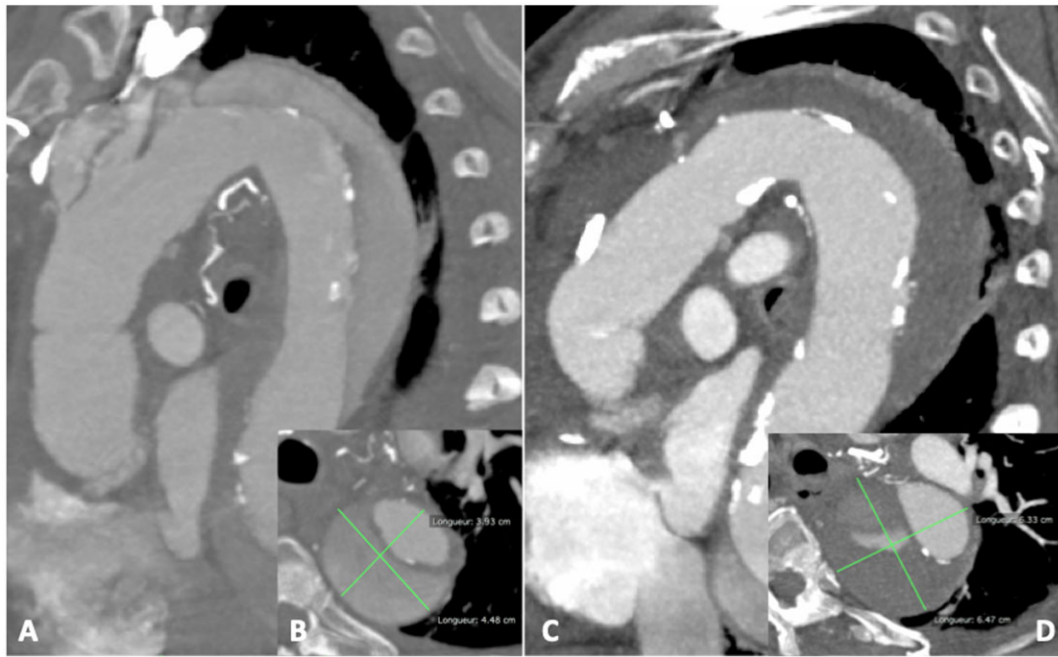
Aneurysmal evolution of the distal descending thoracic aorta. (A) Immediate postoperative CT scan with a sagittal view. (B) Immediate postoperative CT scan with an axial view in the centerline. (C) 1-year postoperative CT scan with a sagittal view. (D) 1-year postoperative CT scan with an axial view in the centerline.
